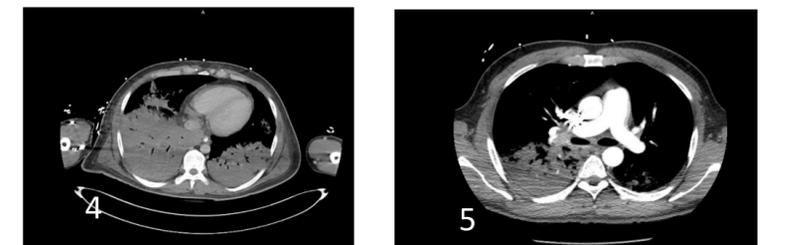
and 4 shows large bilateral consolidations which are substantially worsened compared to prior CT scan findings. Heterogeneous hypodensity in the right lower lobe may represent a pulmonary abscess.
